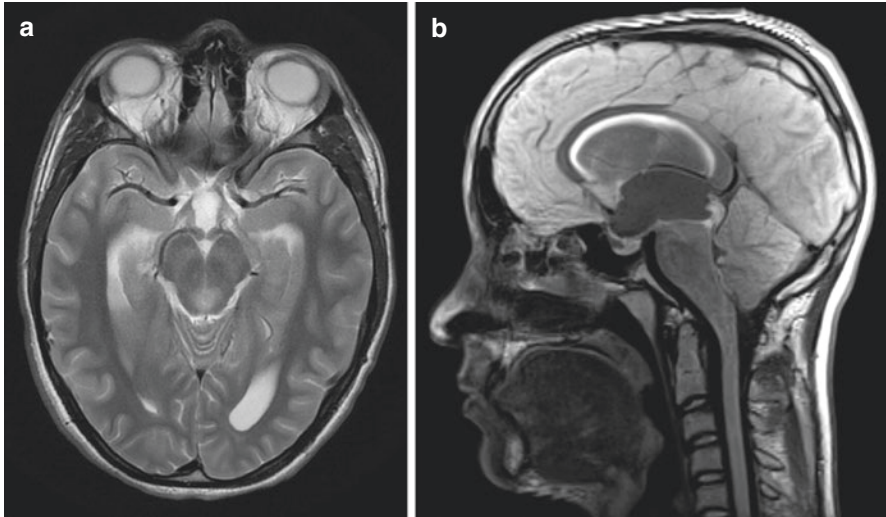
Mesencephalic Brainstem Tumor. (a) Axial T2 weighted MRI demonstrating a T2 hyperintense lesion around the aqueduct of Sylvius with enlarged temporal horns and left atrium. (b) Sagittal FLAIR MRI demonstrating a large mesencephalic glioma
